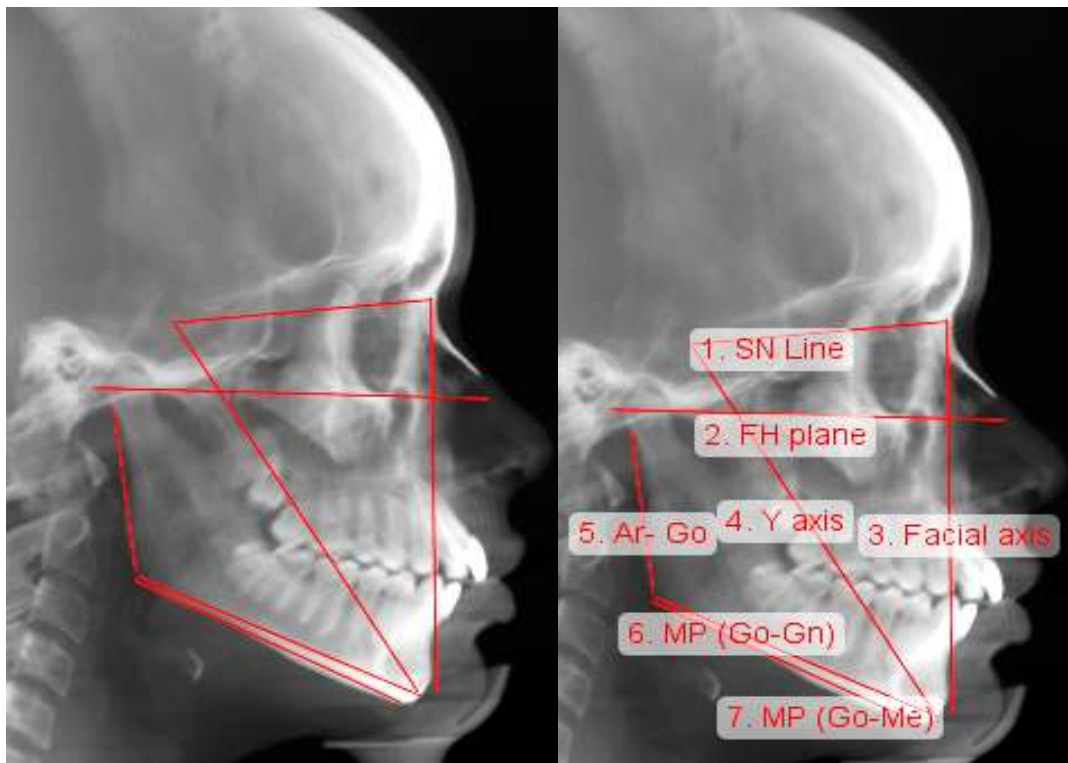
Point and lines drawn on extracted lateral cephalometric radiograph 1. SN line, 2. Frankfurt Horizontal plane(FHP), 3. Facial axis (N-Pog), 4. Y-axis (S-Gn), 5. Ar-Go, 6. Mandibular plane (MP)(GO-Gn), 7. Mandibular plane(MP)(Go-Me).
